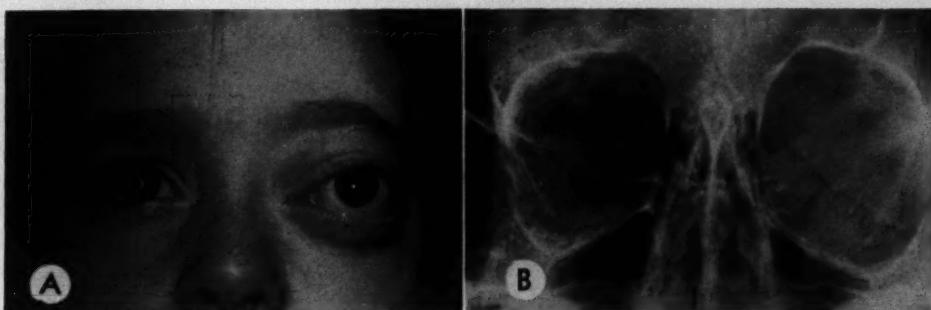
(Jones). Case 46. (A) Exophthalmos following trauma to the left eye. Surgery revealed a blood cyst in a lymphangioma. (B) X-ray film, showing orbital enlargement in this same patient.
